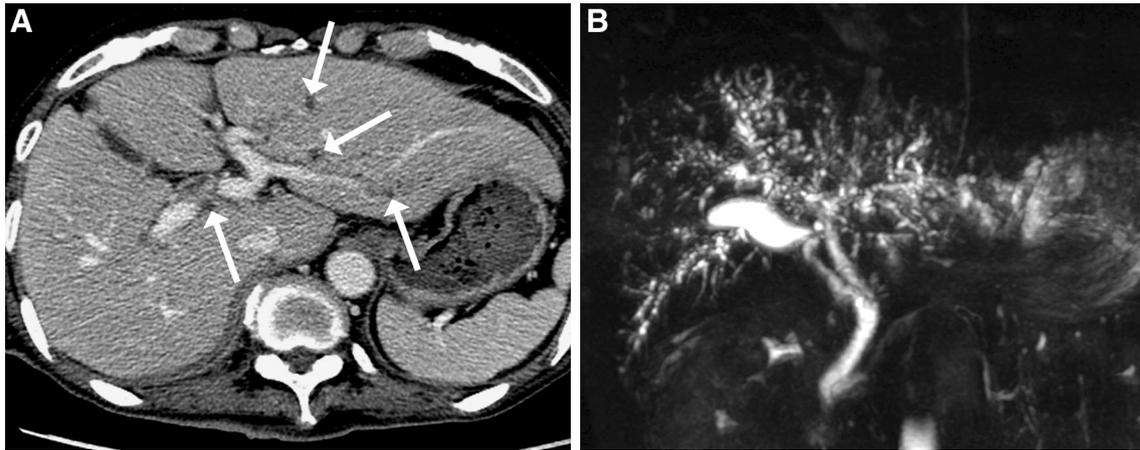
A 66-year-old man who underwent bilateral lung transplantation for idiopathic pulmonary fibrosis. A CT image obtained 56 days after lung transplantation shows multifocal small cystic lesions (arrows) along the expected bilateral intrahepatic bile duct course, suggesting IHD dilatation. Bile
